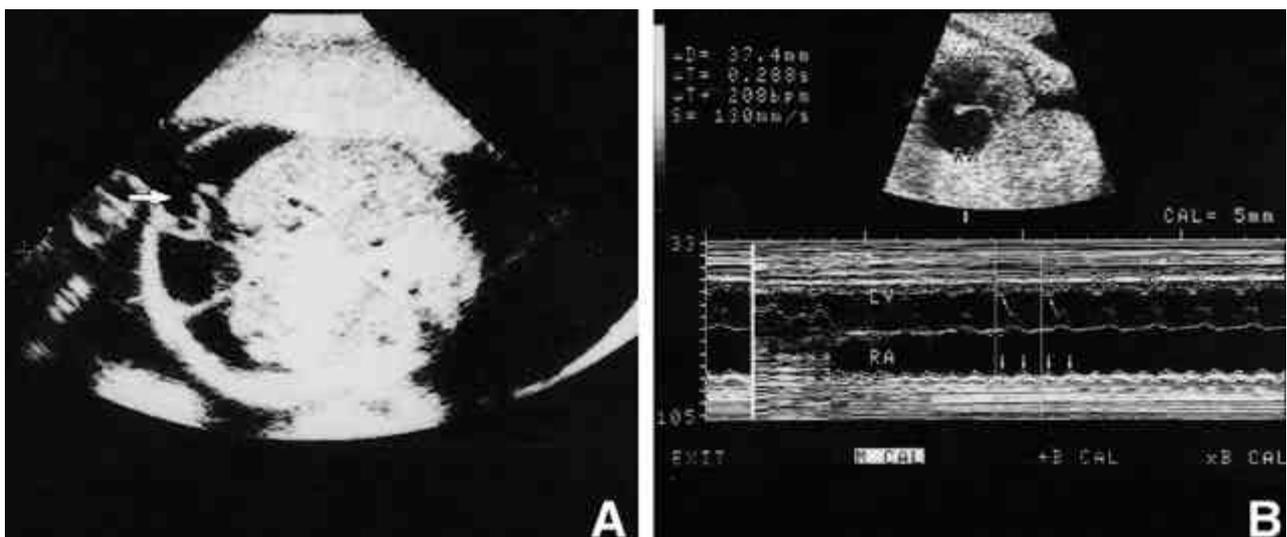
Case 2. A: Initial ultrasonography shows hydrops fetalis (arrow: ascites). B: Fetal cardiac M-mode shows atrial flutter recorded atrial beat 380-420 bpm with 2:1 atrioventricular relation.
